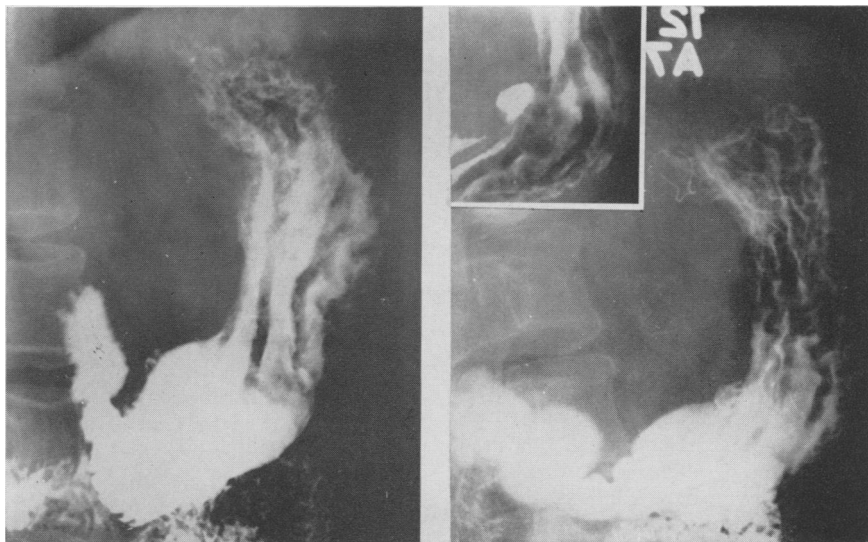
(Left). Gastroduodenal x-ray of O. W. B. (Case 1) taken March 6, 1951 before portacaval shunt. No ulcers are seen.
